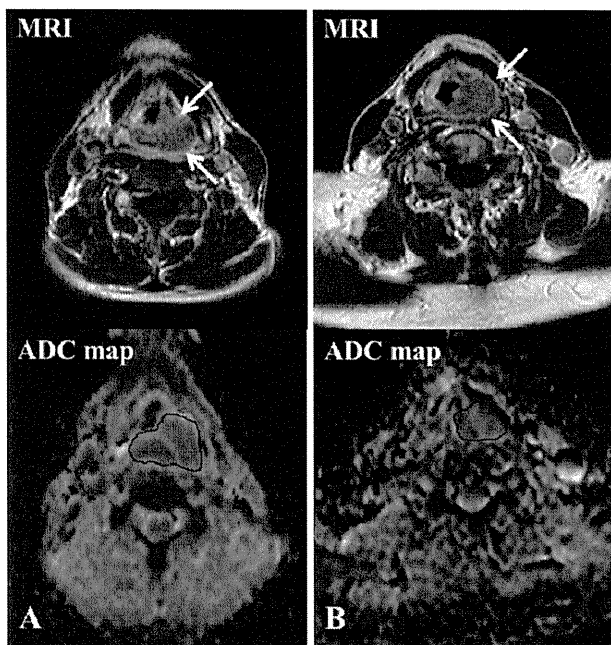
MR images of the two patients with squamous cell carcinoma of the hypopharynx. Contrast-enhanced T1-weighted images (*upper images*) show primary tumors (*arrows*). ADC values were calculated using region-of-interest on ADC maps (*lower images*). (A) A 50-year-old man with T3N0M0 disease. The gross tumor volume of the primary tumor (pGTV) was 21.7 cm³. The ADC value was 0.86×10^{-3} mm²/s. The patient experienced local failure 7 months after the treatment. (B) A 80-year-old man with T3N2bM0 disease. The pGTV was 21.6 cm³. The ADC value was 0.75×10^{-3} mm²/s. The patient has local control 13 months after the treatment.
